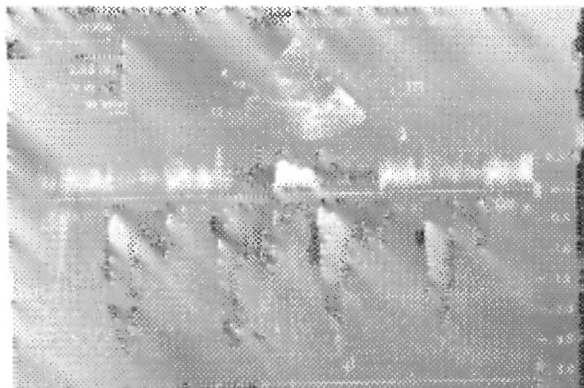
CWF Doppler echocardiographic examination apical 4 chamber view showing tricuspid valve regurgitation with a maximum velocity of 2.88 m/s with recorded pressure gradient of 33.18 mm Hg giving rise to an estimated systolic pulmonary artery pressure (ESPAP) of 43.18 mm Hg.
